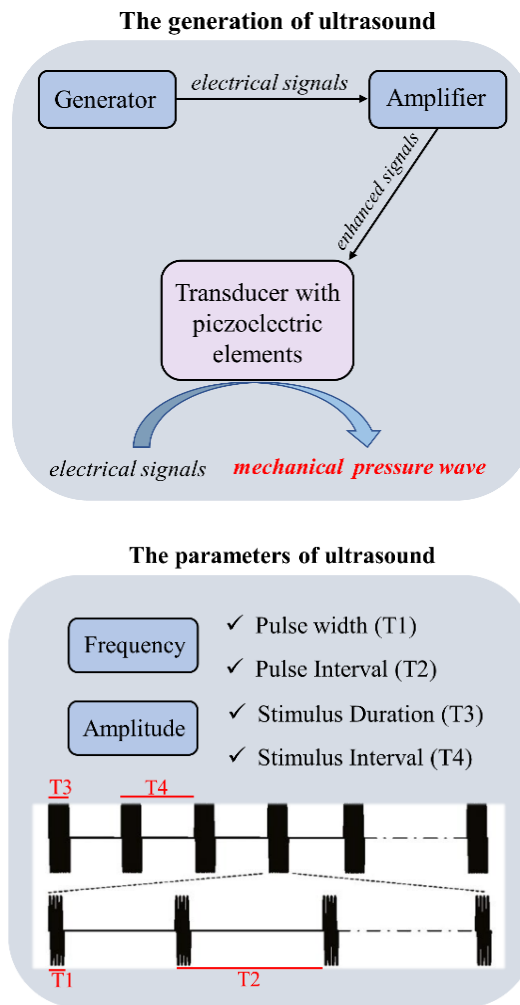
The generation and parameters of ultrasound.
